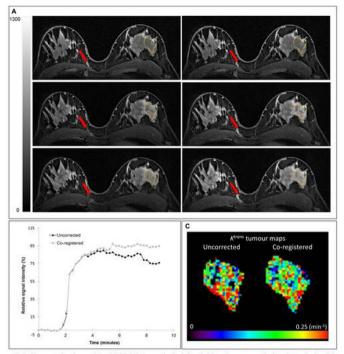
Uncorrected and co-registered DCE MR images in the left and right columns, respectively, prior to (top) and 2 (middle) and 6 (bottom) minutes after contrast agent injection (A). The yellow RO1 placed within the enhancing breast tumour of the left breast was drawn in the 2 minutes post-contrast image (middle). After motion correction the tumour was no longer spatially displaced and also small vessels did not appear blurred (red arrow). Difference in mean relative single intensity-time curves from the RO1 of the uncorrected (black) and corrected (grey) is shown in B. The uncorrected and co-registered *R*^{nom} tumour maps are shown to the left and right (median *R*^{nom}=0.18 and 0.16 min⁻¹), respectively in C.
